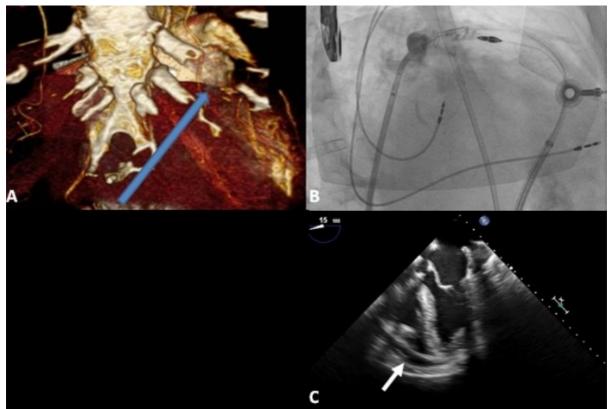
A. Reconstructed CT scan demonstrating anatomic relationship of the LAA and the ideal trajectory of the sub-xiphoid epicardial puncture. B. Contrast injection into the LAA os after closure of the Lariat suture showing no flow into the appendage. C. Intra-operative TEE prior to LAA closure demonstrates pericardial effusion.
